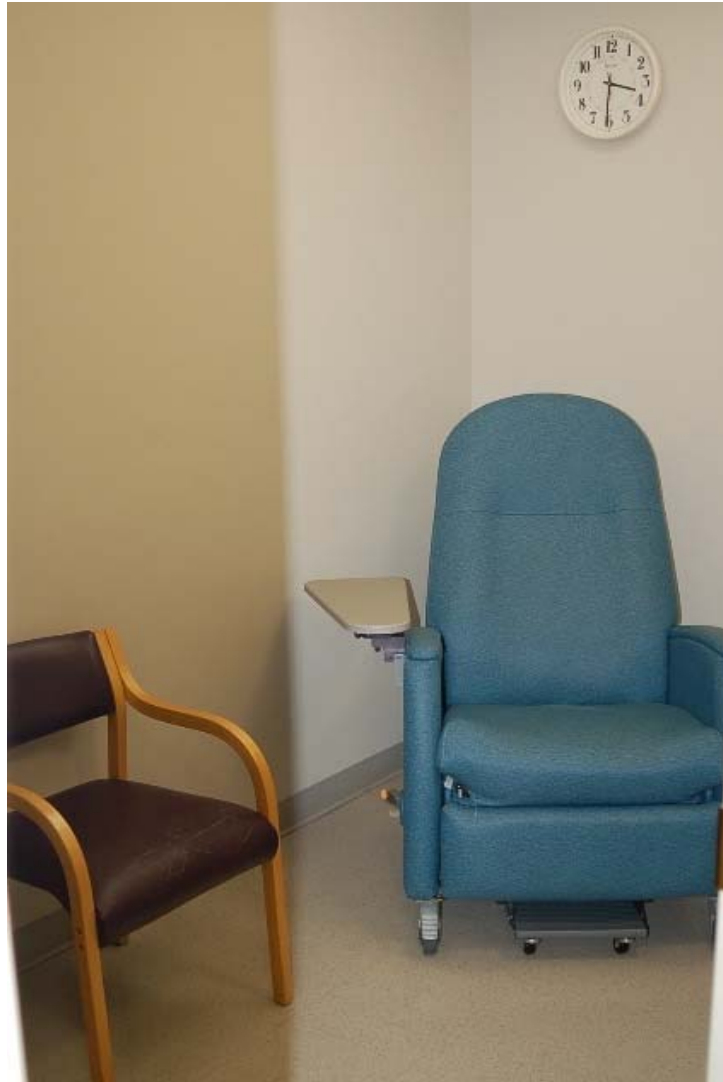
Patient Prep Room in TKC PET/CT Center Adjacent to the Outer Corridor.
